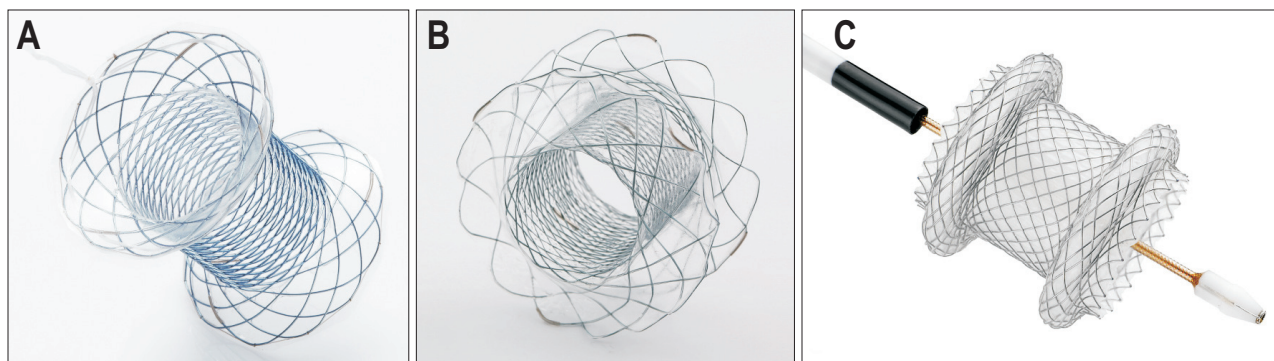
Endoscopic ultrasound-specific stent systems: (A) NAGI stent, (B) Spaxus stent, and (C) Hot AXIOS stent.
